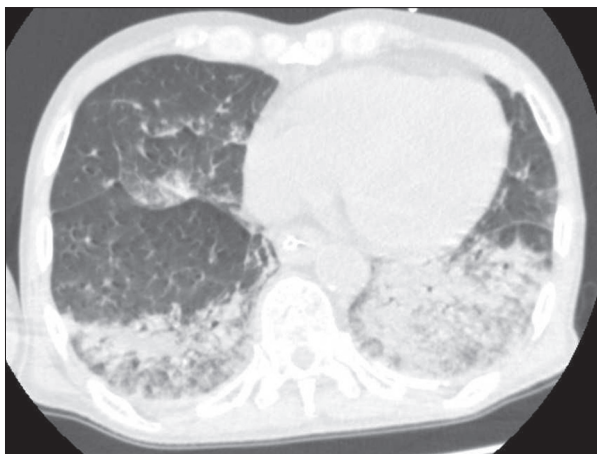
Computed tomography (CT) at admission revealed bilateral pulmonary edema.
